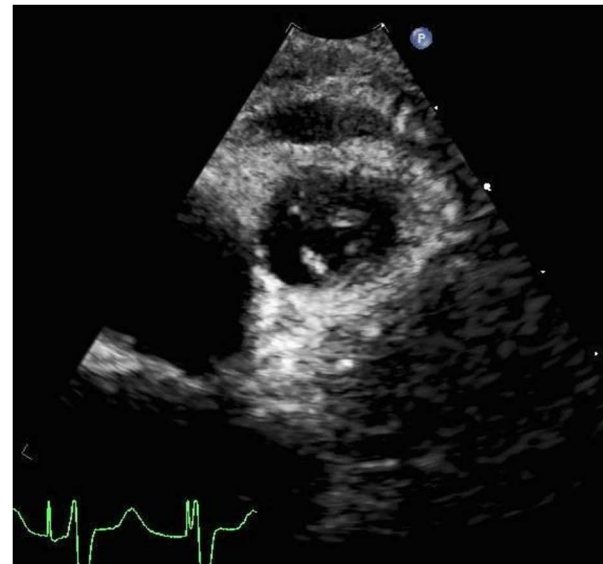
Parasternal short-access image demonstrating an isolated absent pulmonary valve. In addition, one notes significant dilation of the branch pulmonary arteries. RPA = right pulmonary artery; LPA = left pulmonary artery.
